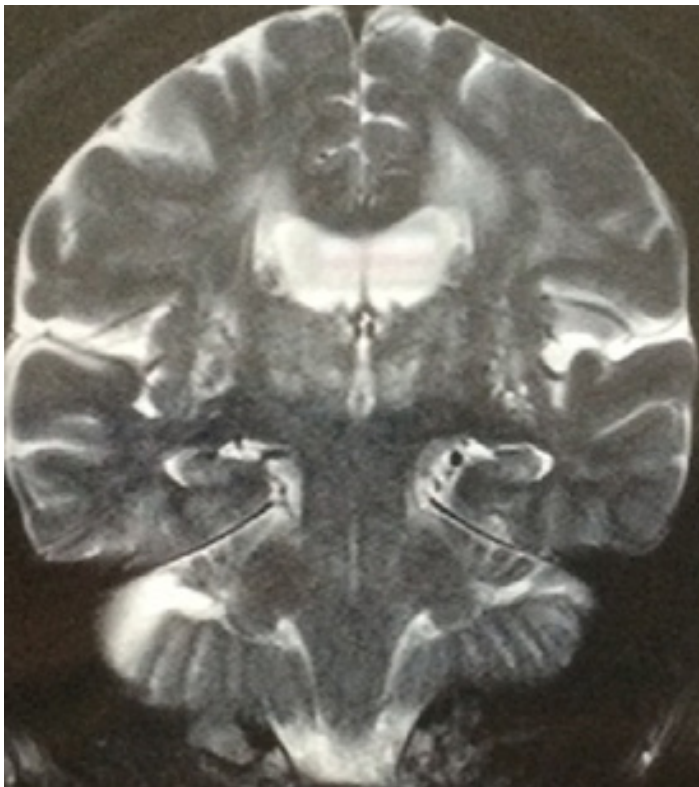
Brain- T2-MRI- Leukoencephalopathy characterized by diffuse and confluent hyperintense lesions in the white matter, periventricular region, external capsule and basal nuclei.
